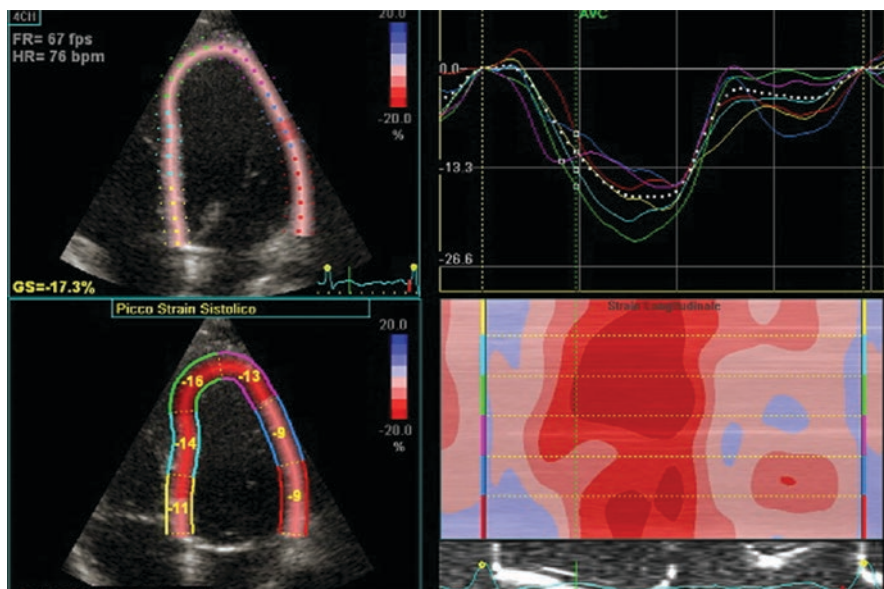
2D STE measurement of longitudinal strain in apical 4-chamber view in a patient with myocarditis
